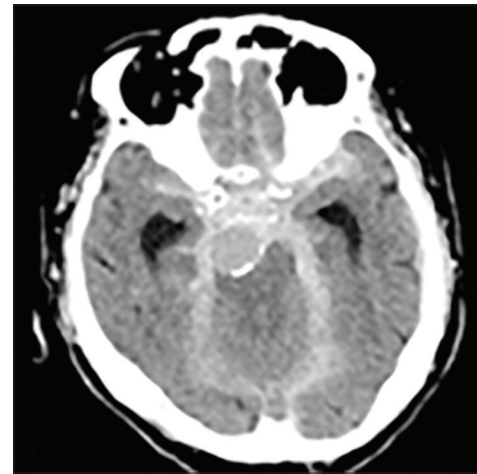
Computed tomography showing a massive subarachnoid hemorrhage in the posterior fossa.
